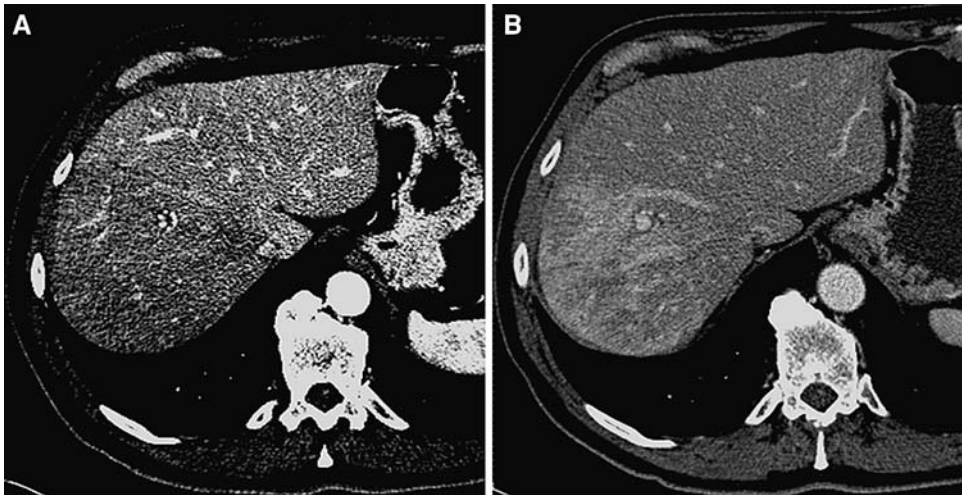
(A) Contrast-enhanced CT in the arterial phase demonstrates diffuse hypoattenuating parenchyma in the right hepatic lobe distribution following Y90. (B) In a different patient from (A), contrast-enhanced CT scan demonstrates parenchymal hyperenhancement from radiation effect in the right hepatic artery distribution following treatment for a right lobe hepatoma.
